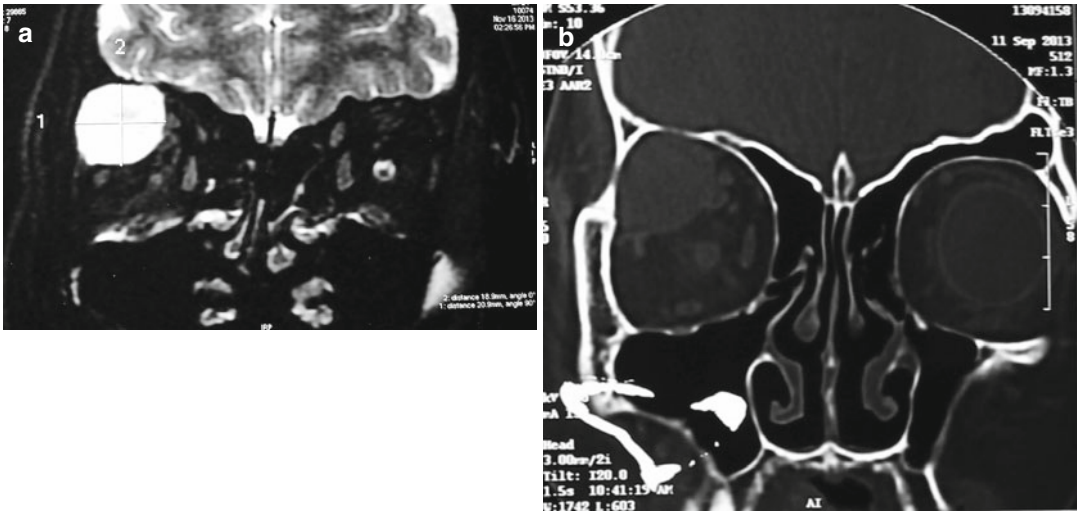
T2-weighted coronal MRI scan showing a well-circumscribed round soft tissue lesion in the right lacrimal gland fossa (a); CT scan of the same patient showing fossa formation without bony erosion or calcification (b)
